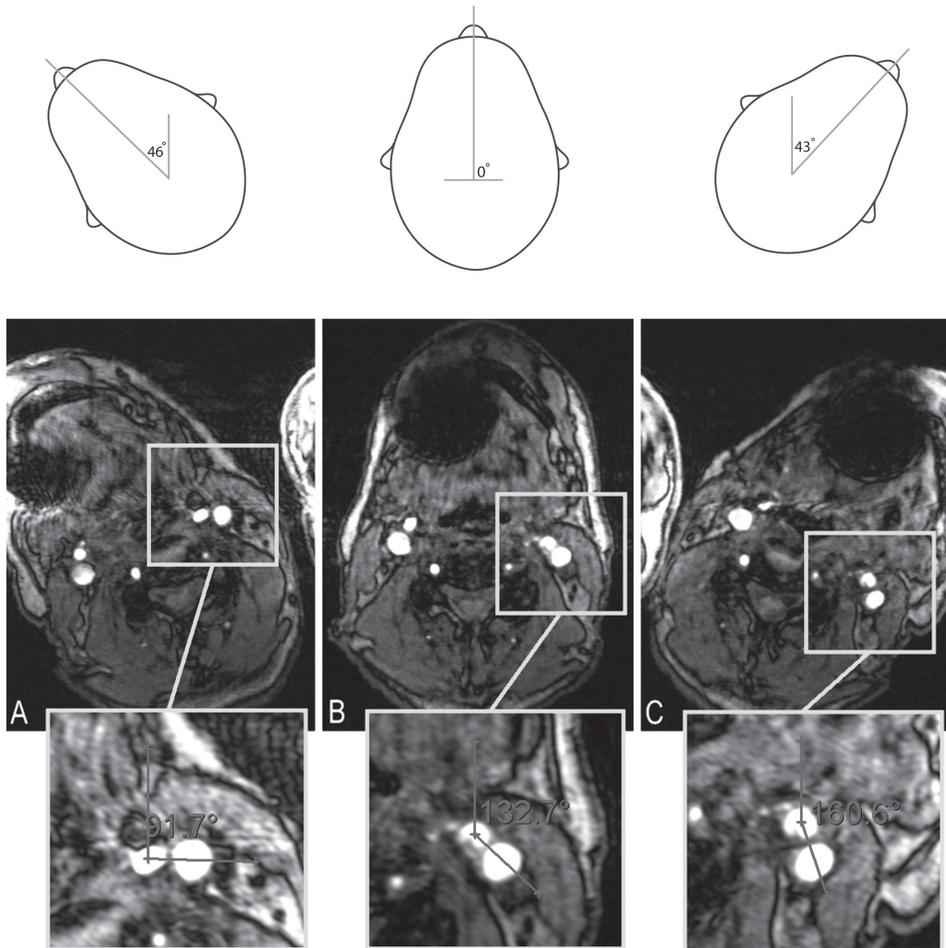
MR images of a 69-year-old man following stent placement in the left internal carotid artery. Transverse sections at the level of the bifurcation in different head positions: turned Right (A), Neutral (B) and turned Left (C), were used to measure torsion of the carotid artery. Common carotid artery torsion = rotation of the bifurcation. Internal carotid artery torsion = head rotation minus rotation of the bifurcation.
